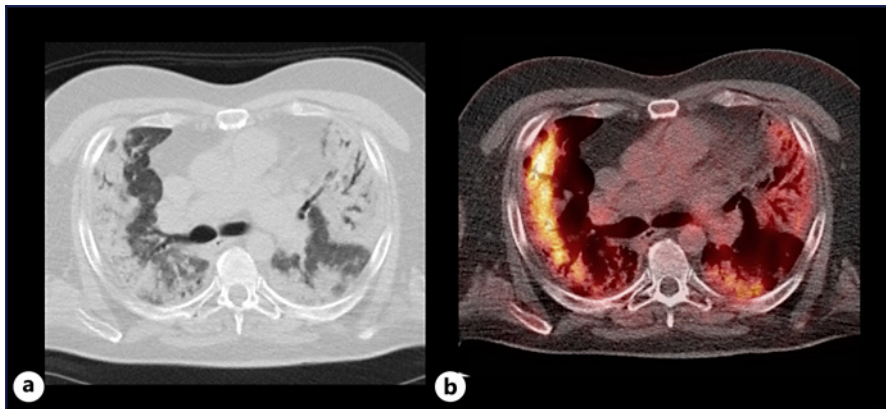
a Chest CT scan in March 2018 prior to LTx. b Corresponding ^{18}F -FDG PET image. CT, computed tomography; PET, positron emission tomography. Moderate hypermetabolic consolidations bilaterally in the lungs. Accompanying mildly hypermetabolic glands bilaterally hilar and mediastinal.
